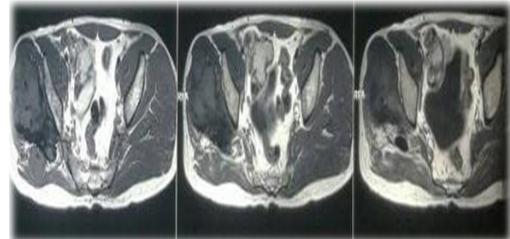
MRI of right hip and pelvis
